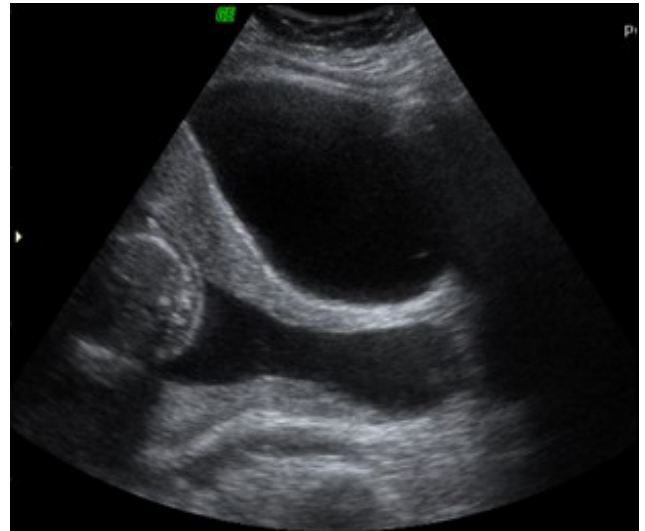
Transabdominal ultrasonography shows that herniated amniotic membranes, defined as advanced cervical change and protrusion, protrude from the cervix more distally than the urethra entrance of the bladder.
